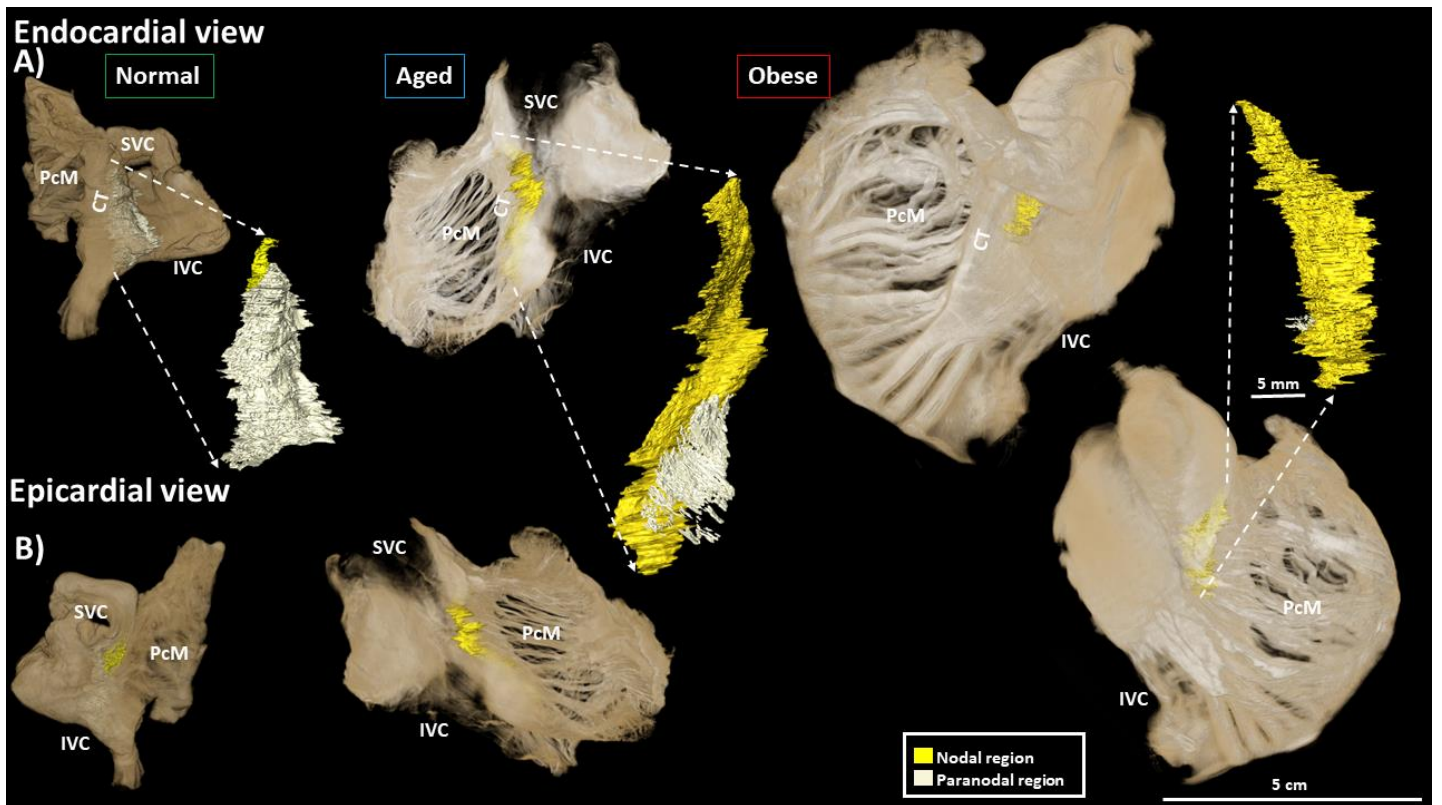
Segmentation of paranodal area (white) and the low attenuation (yellow) difference regions in the normal, aged and obese right atrium blocks. Within the yellow region is the location of the sinus node. (A) Endocardial view. (B) Epicardial view. CT = crista terminalis; IVC = inferior vena cava; PcM = pectinate muscle; SVC = superior vena cava.
